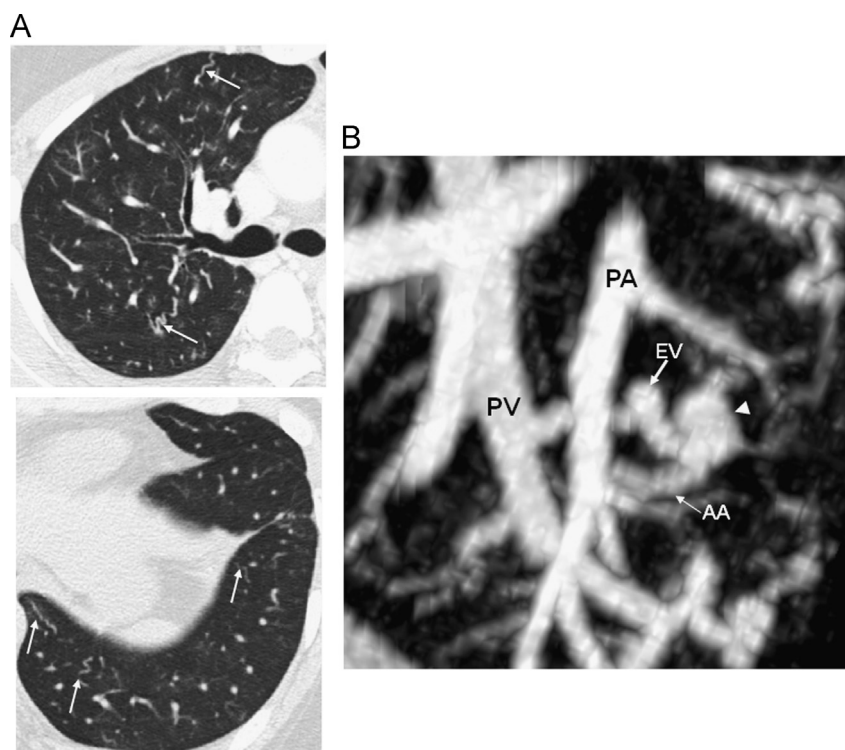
(A) Chest HRCT on admission. Multiple meandering feeding vessels (arrows) are found in bilateral lung fields. (B) 3-dimensional reconstruction image of chest CT. A saccular aneurysm (5.8 mm in diameter, arrowhead) with an afferent artery (2.6 mm in diameter) and efferent vein (2.7 mm in diameter) is shown (arrows). PA, pulmonary artery; PV, pulmonary vein; AA, afferent artery; EV, efferent vein.
